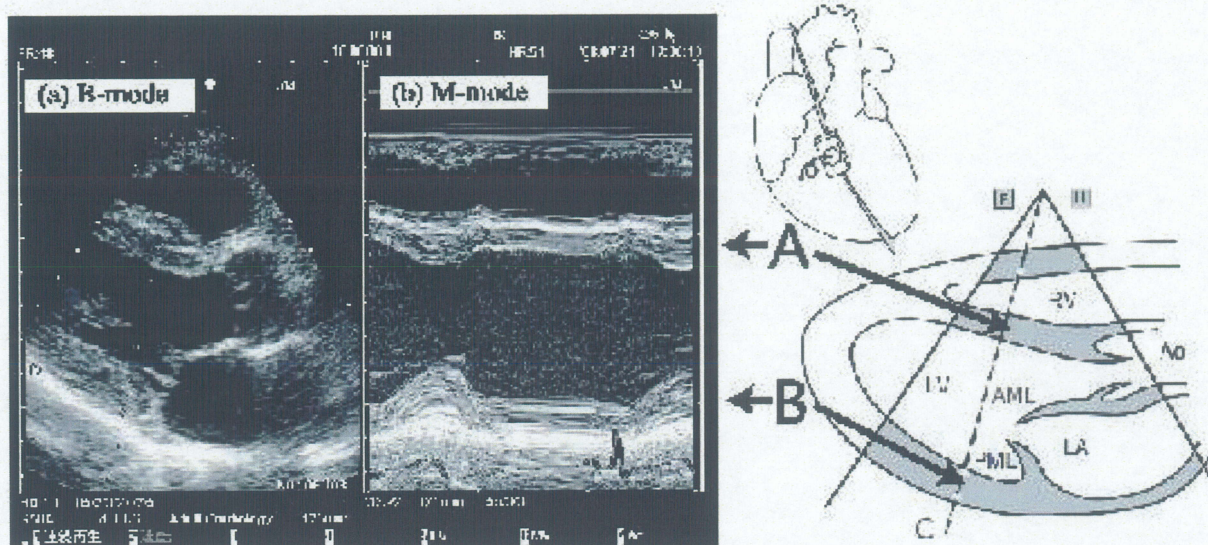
Example of clinical echocardiogram: (a) B-mode, (b) M-mode echocardiogram, A. Interventricular septum and B. Left ventricular posterior wall
